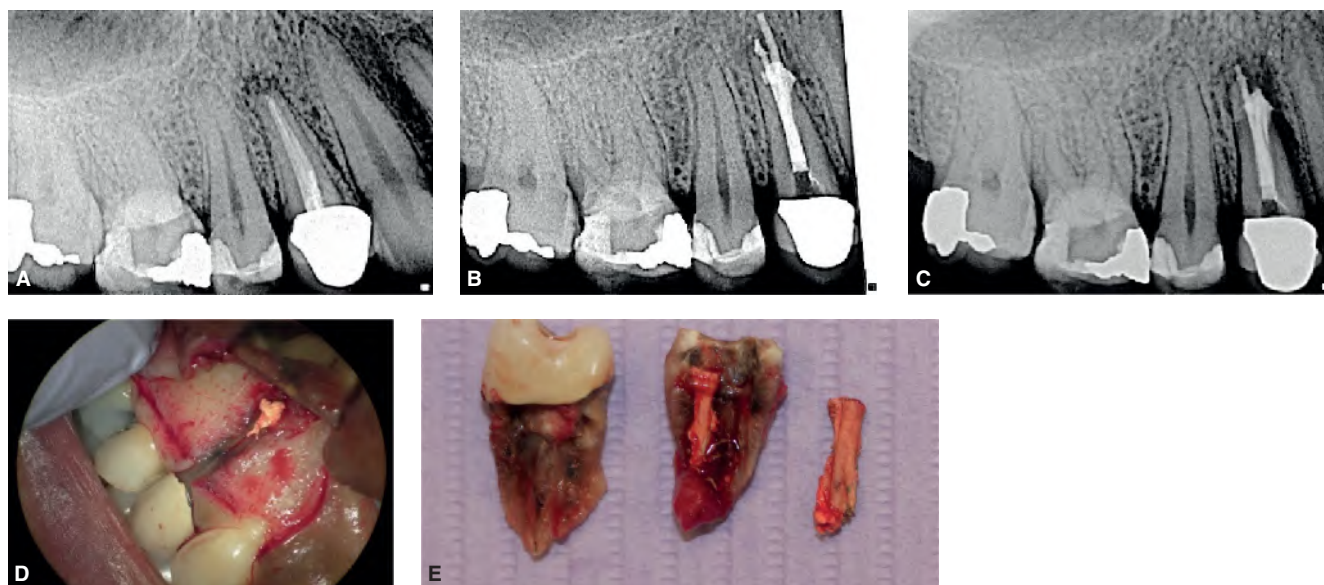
Retreatment without accurately determining the cause of failure. A. Preoperative radiograph showing periapical radiolucency associated with the maxillary right second premolar that is symptomatic to biting. A deep isolated pocket is present along the buccal root surface. B. Postoperative radiograph showing extensive overfilling. C. 6-month follow-up radiograph indicates that retreatment has failed. Since the cause of failure was not determined preoperatively, the clinician proceeded to periapical surgery. D. Intraoral image after flap reflection indicates a split in the root. The tooth is hopeless and requires extraction. E. The tooth following extraction.
